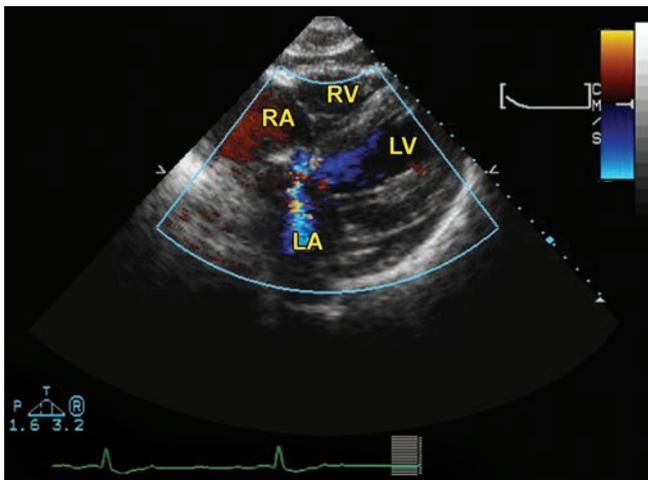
Color Doppler flow image in transthoracic subcostal view revealing a jet that mimics mitral regurgitation. This jet actually represents the right to left shunt between the coronary sinus and left atrium.
